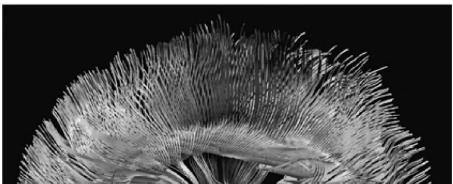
At the top, we see an image taken by a functional MRI machine, showing regions of high mental activity. In the bottom image, we see the flowerlike pattern created by a diffusion MRI machine, which can follow the neural pathways and connections of the brain.
